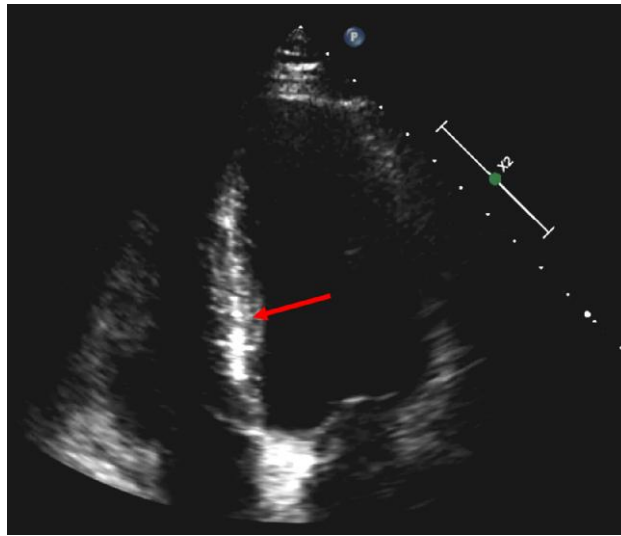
Transthoracic echocardiogram showing echogenic myocardium in the antero-septal wall (arrow).
